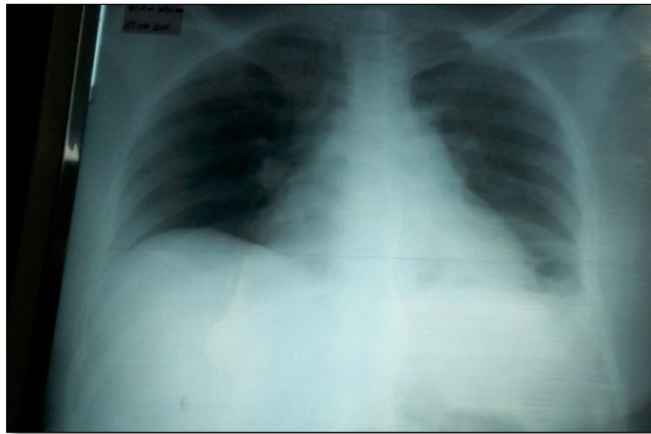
Post-operative J2 chest x-ray showing lung re-expansion and recurrence of right diaphragmatic dome.
